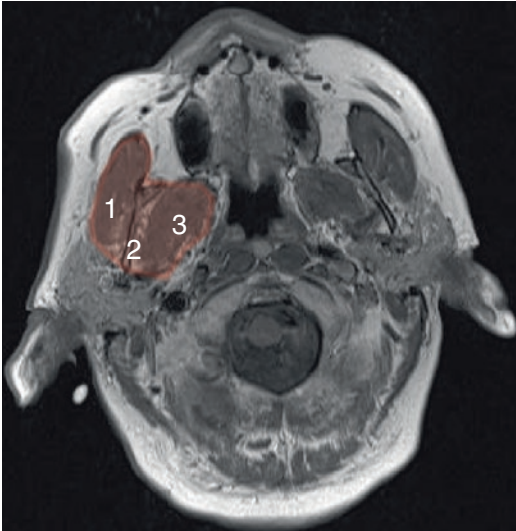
Axial T1W MRI suprahyoid neck. The red-shaded area indicates the MMM sandwich of the right masticator space: (1) masseter, (2) mandible, (3) medial pterygoid
